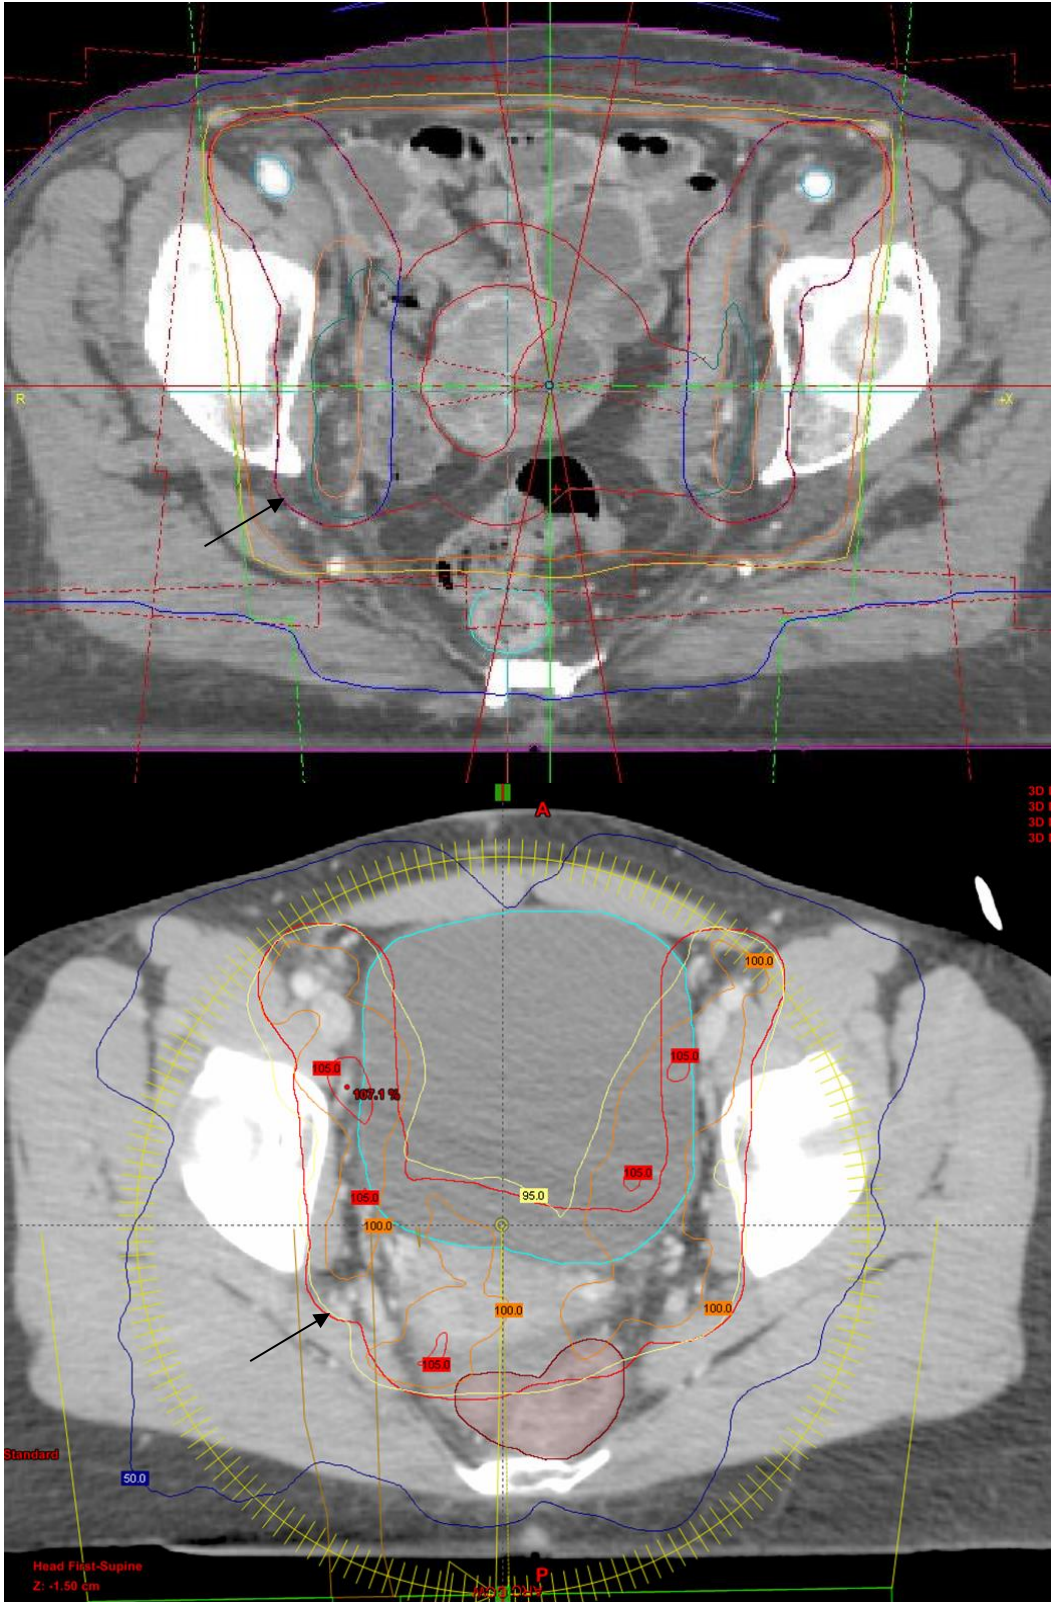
Transverse CT images showing the dose distribution of 3D-CRT (top) versus IMRT (bottom) for cervical RT. Yellow line=95% prescribed dose, orange=100%, red=105%, blue=50%. Red structure arrowed(u shaped)=PTV. The IMRT plan (bottom) conforms better with concavity anteriorly compared to the 3D-CRT (top) box shape.
